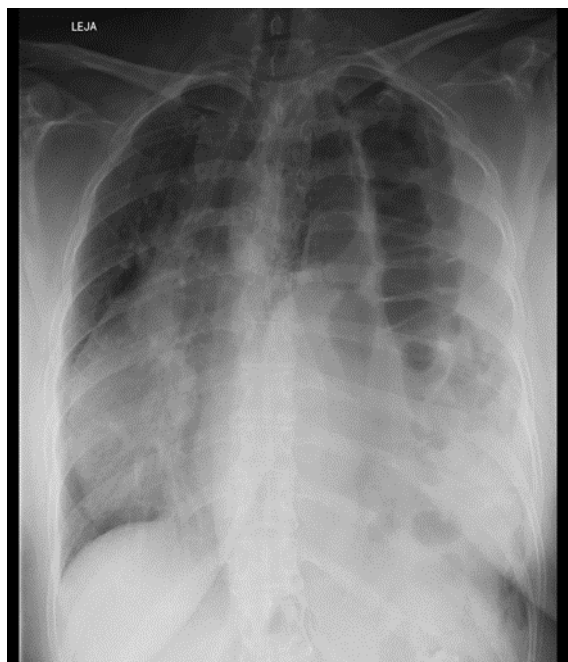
Chest X-ray. Loops of the colon in the left pleural cavity, displacement of the mediastinum in the opposite direction, flattening and deformation of the left cupula of the diaphragm
